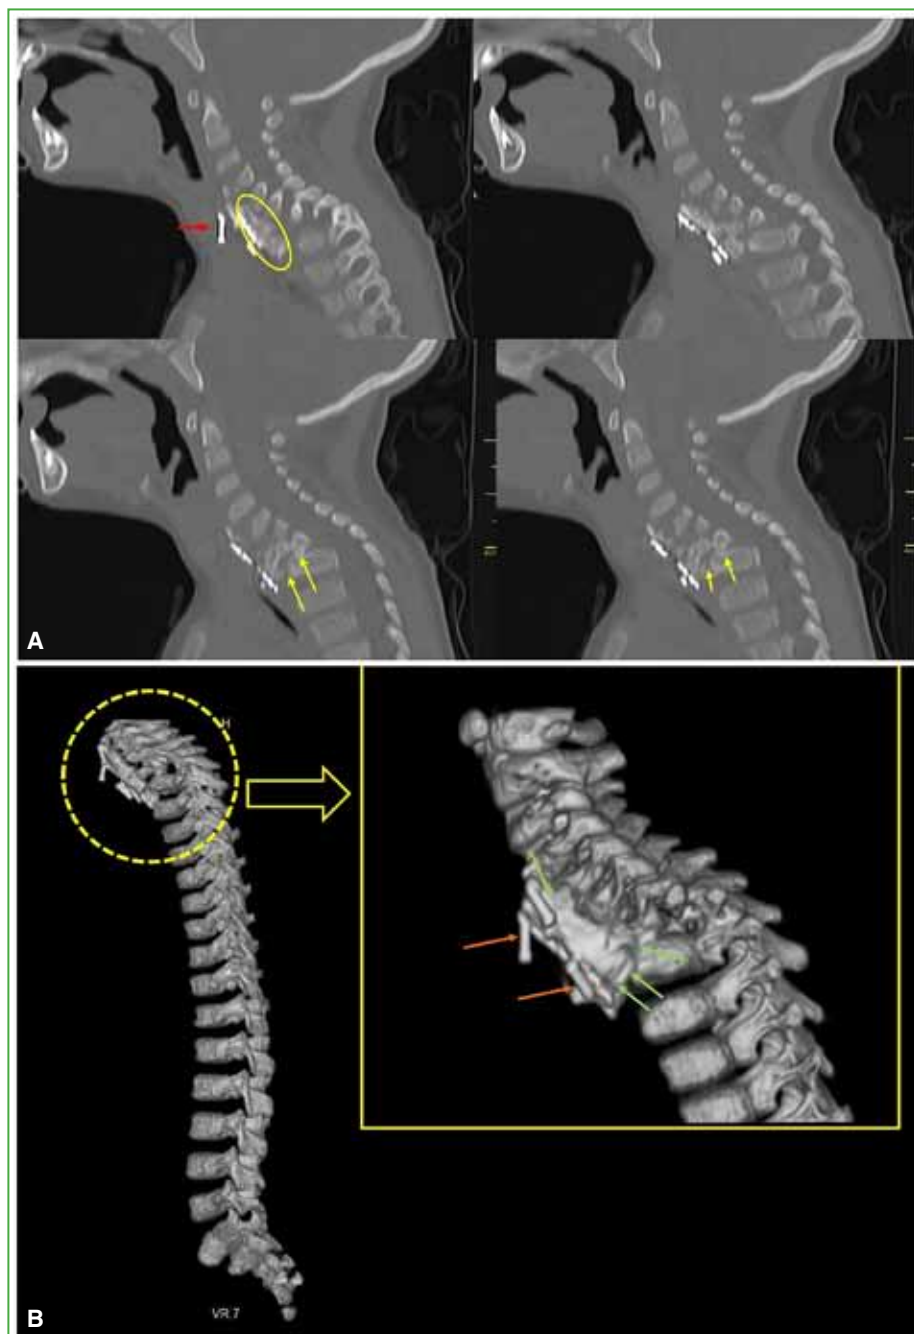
Control CT scan of the cervico-thoracic spine at 1 year and 10 months after surgery. A. Note intersomatic fusion (yellow arrows), significant anterior bony bridging (yellow oval), instrumentation disassembly (red arrow), and segmental kyphosis. B. 3D reconstruction. In the inset, the important fusion mass stabilizing the region can be seen.
